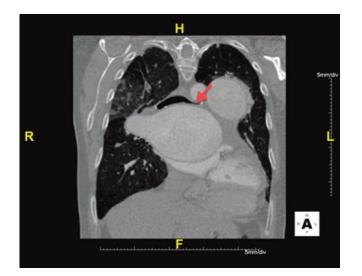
Contrast-enhanced computed tomography of the chest reconstructed in the coronal plane of patient A showing left main bronchus compression (arrow) by an enlarged main pulmonary artery.
